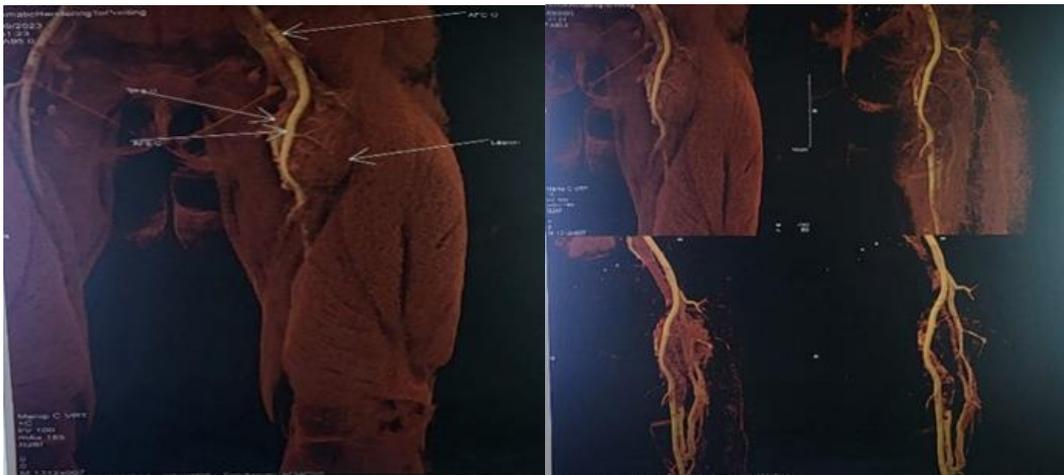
MRI angiography: Endovascular tumour process of the left femoral vein, suggesting in the first instance a leiomyosarcoma encompassing the femoral artery
